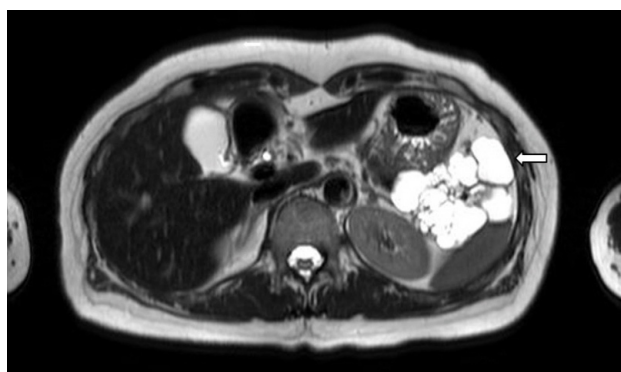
Pancreatic magnetic resonance imaging (T2-weighted axial image) revealed an 8 cm-sized lobulated multilocular cyst in the pancreatic tail (arrow).
